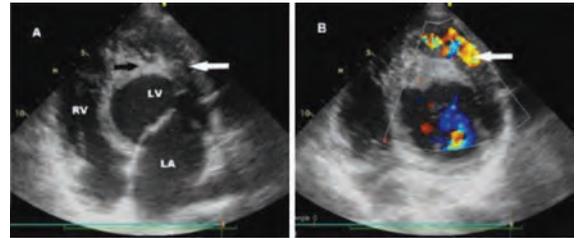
A. Apical 4 chamber images of the patient. Black arrow: Mass appearance in the papillary muscles. White arrow: Two layered structure. B. Color-Doppler appearance of inter-trabecular blood flow (white arrow). LV: Left ventricle, LA: Left atrium, RV: Right ventricle.
